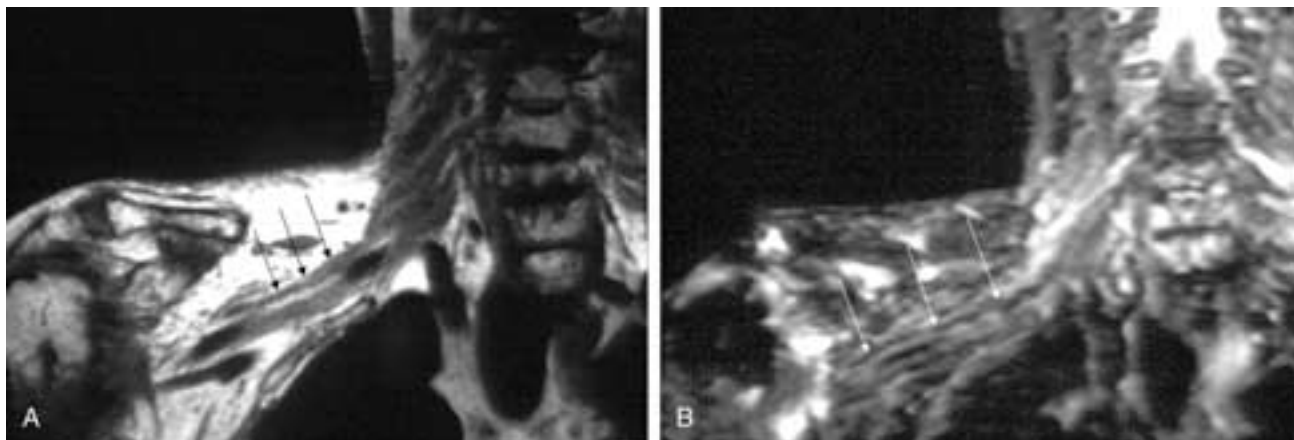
Radiation fibrosis. Status postradiation therapy for breast cancer. T1-weighted (A) and T2-weighted fat-suppressed (B) coronal MR images demonstrate a sharply margined area of thickening adjacent to the brachial plexus (arrows). This area is isointense to muscle on both sequences.
